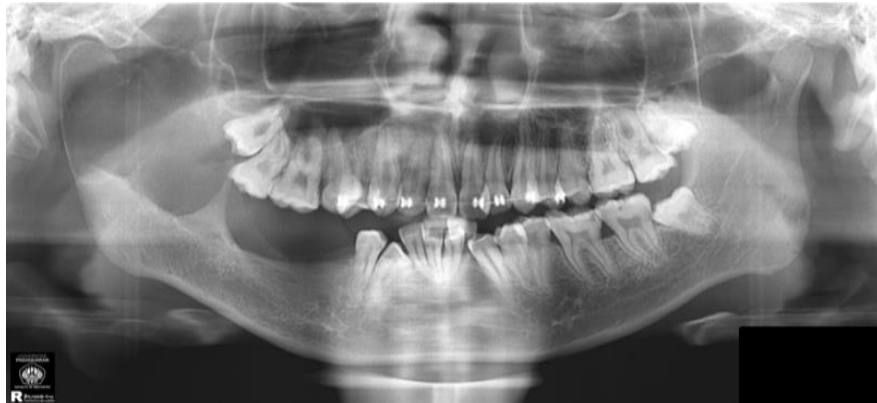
2 Panoramic radiograph of the patient. It is seen that the mandibular posterior teeth disappeared after marsupialization therapy 6 years ago. A new mass was seen in the right STM area to the right mandibular ramus area
